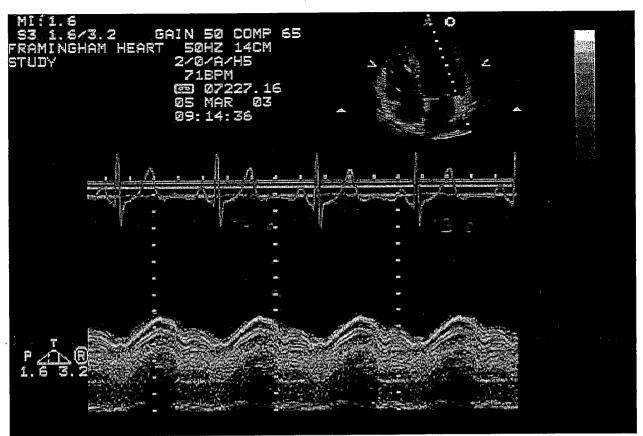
Example of M-Mode Apical Four-Chamber view of MV annulus. Apical Four-chamber is on-axis, cursor placed in correct position at MV annulus. Clear echoes of MV annulus movements (optimal image).
